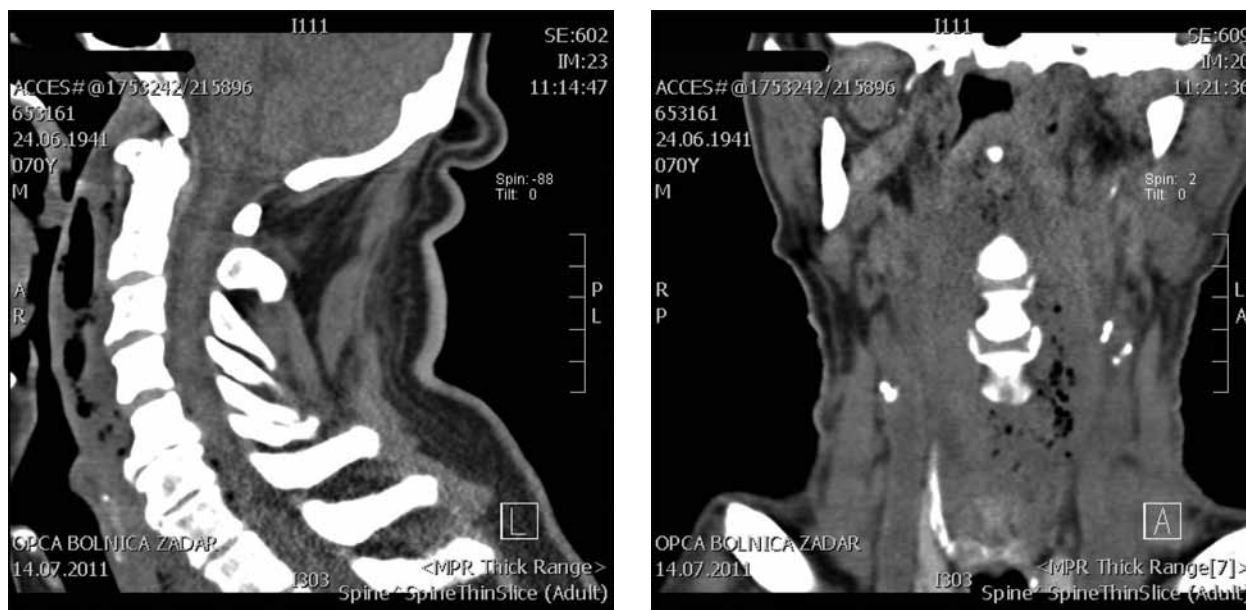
Computed tomography (CT) on the day of admission revealed thickening of the retropharyngeal space with a collection of air (A, sagittal view; B, frontal view).
